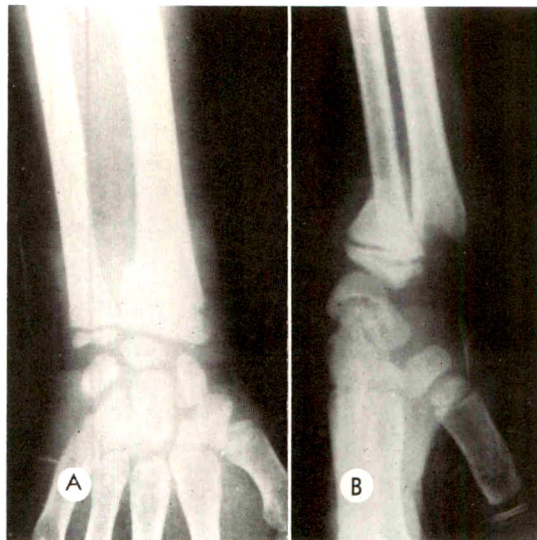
Case 1. (A) Posteroanterior and (B) lateral roentgenograms of the right wrist show a fracture of the distal shaft of the radius. The ulnar epiphysis appears to be intact.
